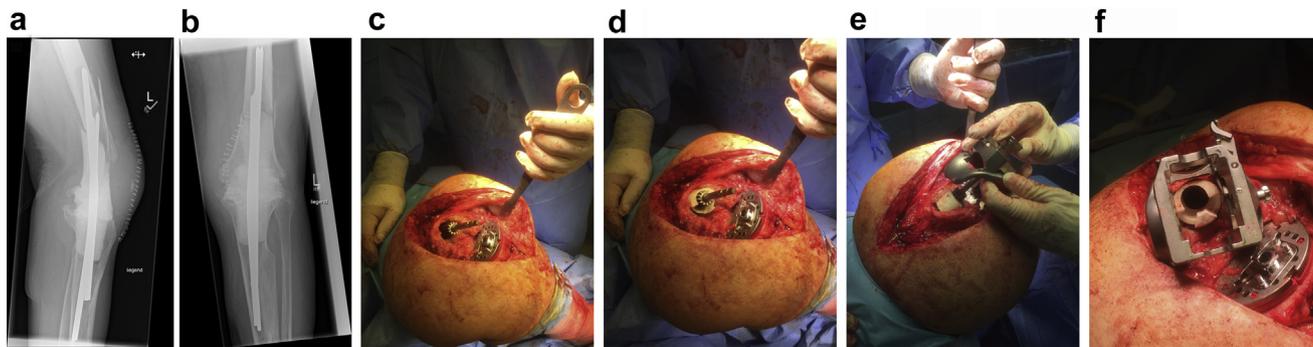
(a) Antero-posterior (AP) (a) and lateral (b) preoperative radiograph of the knee of an 80-year-old patient with a static spacer after removing a well-fixed, infected hinge prosthesis with long cemented stems showing fracture of the distal femur. Intraoperative photograph after implanting the trial tibial component and positioning the femoral intramedullary reamer for alignment; note that an additional longitudinal posterior femoral fracture is seen (c). Placement of the trial trabecular metal cone of the reamer for filling the defect, and distraction osteosynthesis of the femoral longitudinal fracture (d). Positioning of the trial implant with augments to reconstruct the correct joint line (e). Placement of the trial implant to check whether box preparation interferes with the cone (f). Impacting in the chosen cone of the reamer as an alignment guide (g). Positioning of the trial implant with augments to reconstruct the correct joint line for control (h). Cementing in the final implants before combining the two components with the inlay and the axis (i,j). Postoperative AP (k) and lateral (l) radiographs at 2-year follow-up showing partially healed fractures and incorporated cones.
